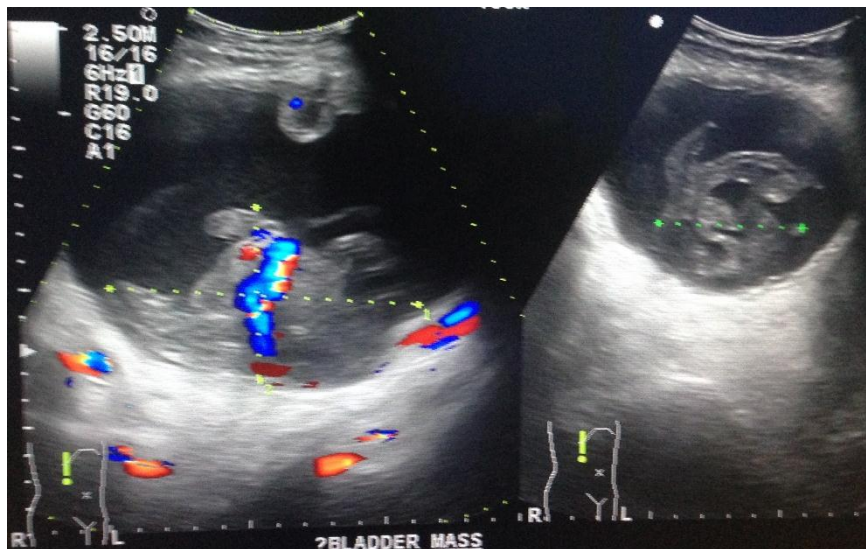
bladder ultrasound image of a 75 year old man. The prostate is markedly enlarged and protrudes into the bladder lumen. There is an additional pedunculated immobile vascularized bladder mass.
